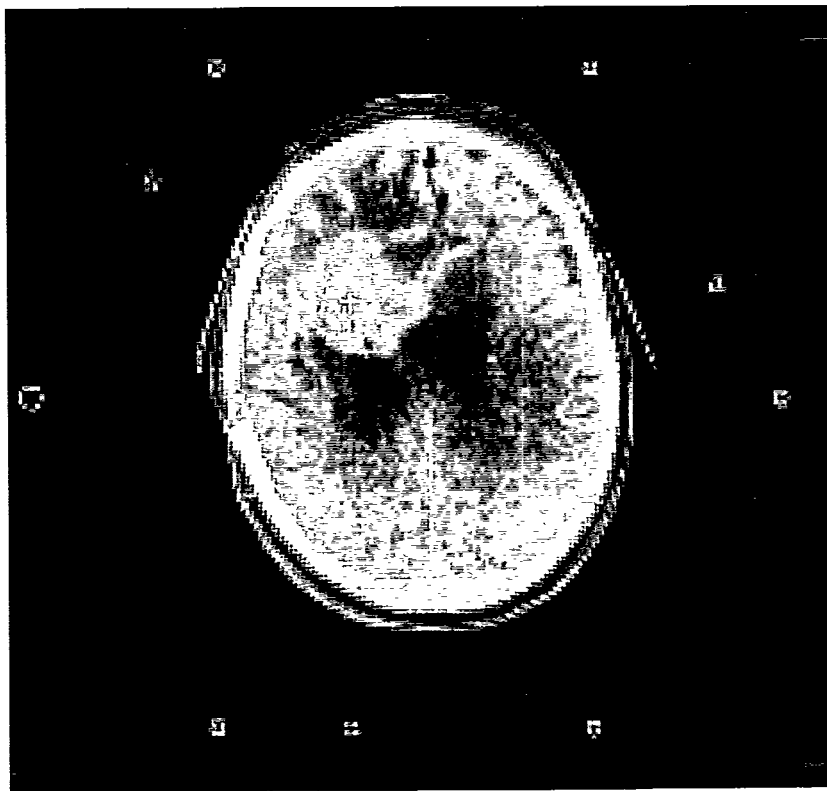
(Top) CT transaxial slice depicting tumor in the top left quadrant. The nine cross sections of the bars of the frame can be seen surrounding the head. (Bottom) The same slice with the activity distribution as imaged at two days postinfusion overlaid. The white cross signifies the point at which the catheter was placed.
